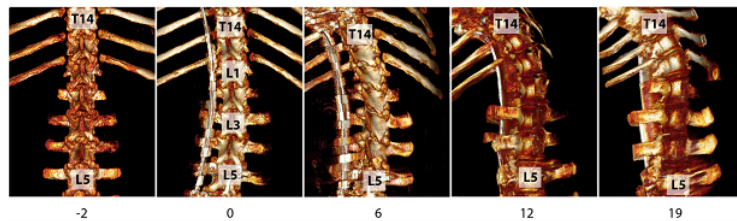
Serial CT reconstructions in weeks post-op demonstrating progressive curvature.
